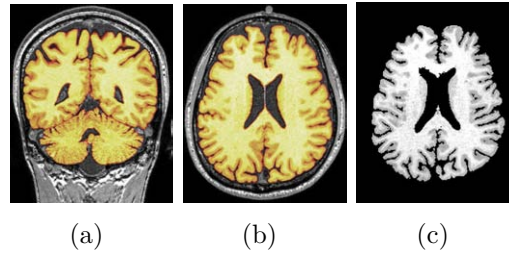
(a) Coronal and (b) Axial slice of the MRI. (c) Extraction of the cerebral parenchyma by the pre-segmentation method.
